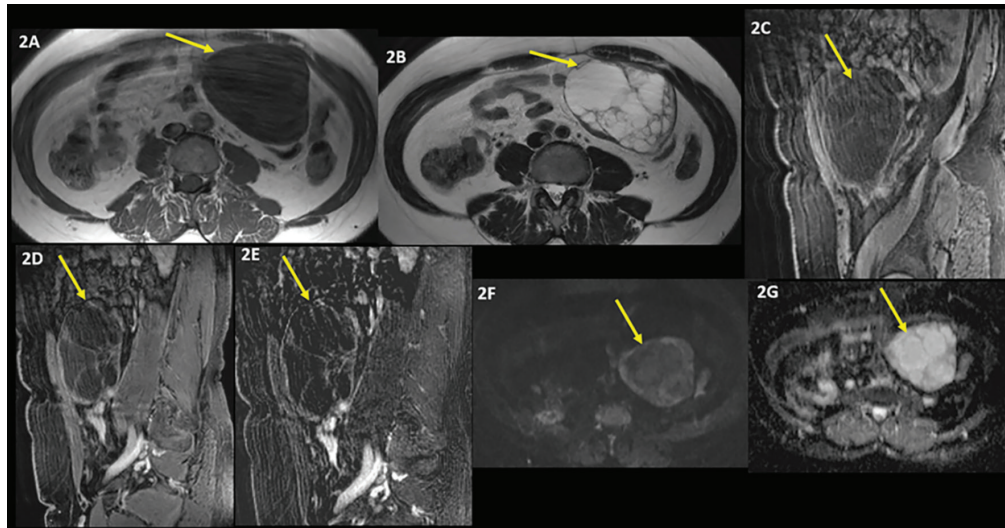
A 57-year-old woman with acne consulted from dermatology. A complicated cystic lesion measuring 102x67x117 mm in the left ovary was observed, exhibiting T1-weighted (T1W) hypointensity (Figure 2A arrow); T2-weighted hyperintensity (Figure 2B arrow); fatsat T1W (Figure 2C arrow) and with multiple septa, measuring 8 mm in the thickest part of the wall. In the postcontrast series, a complicated cystic lesion with minimal enhancement in its wall and septa (Figure 2D arrow and subtraction Figure 2E arrow) and increased diffusion in diffusion-weighted imagings (Figures 2F and 2G arrows) was observed, proven by biopsy mucinous cystadenoma
